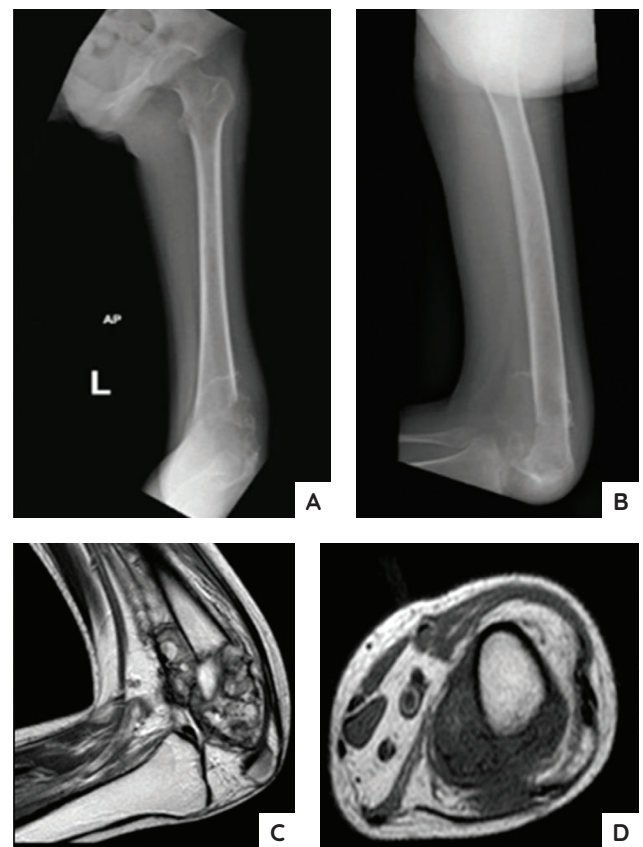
Initial AP (A) and lateral (B) radiographs show an aggressive lytic lesion of the distal femur with a cortical break and soft tissue mass on the lateral aspect. Initial MRI sequences before treatment. T1W FS contrast-enhanced coronal cut (C) and T2W TSE axial cut (D).
